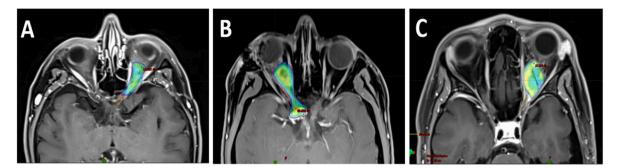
Radiation therapy planning examples. This figure shows three examples of MRI axial images weighed in T1 and enhanced with gadolinium. (A) The left-sided 2.9 cm³ ONSM was treated with 13 Gy SRS due to vision loss. (B) right-sided 5.2 cm³ ONSM treated with 60 Gy FSRT due to vision loss. (C) left sided 3.2 cm³ ONSM treated with 5×5 Gy hSRS for vision preservation. The dose distribution is shown in wash color on the target volume in the three images.
